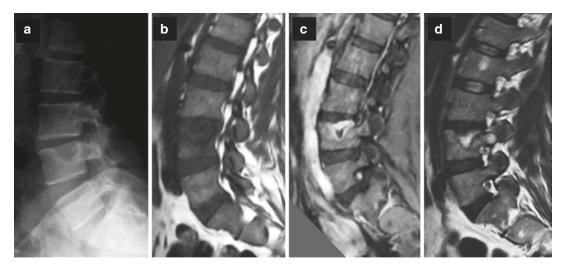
L4 spondylitis with centro-somatic and superior cartilage end plate invasion due to TB. Plain radiography (a), sagittal MRI on T1-weighted image before (b) and after gadolinium injection (c) and on T2-weighted image (d)
